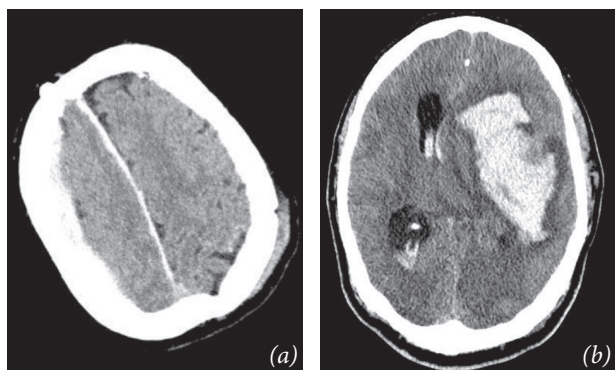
(a) Non-enhanced CT scan of a severe TBI showing a right sided subdural hematoma in a 51-year-old alcoholic after falling from a bicycle. GCS 3 and absent pupillary reactivity; (b) the same patient exhibiting massive subarachnoid hemorrhage.
